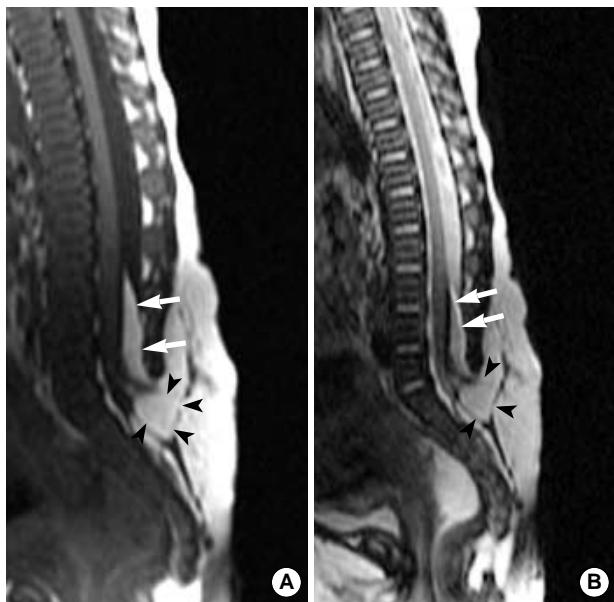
Initial preoperative spine MR of T1-weighted (A) and T2-weighted images (B) shows tethered conus medullaris to the level of sacrum and two isolated lipomyelomeningoceles, a transitional type from L3 to L5 (arrows), and a terminal type below S1 (arrow heads).
